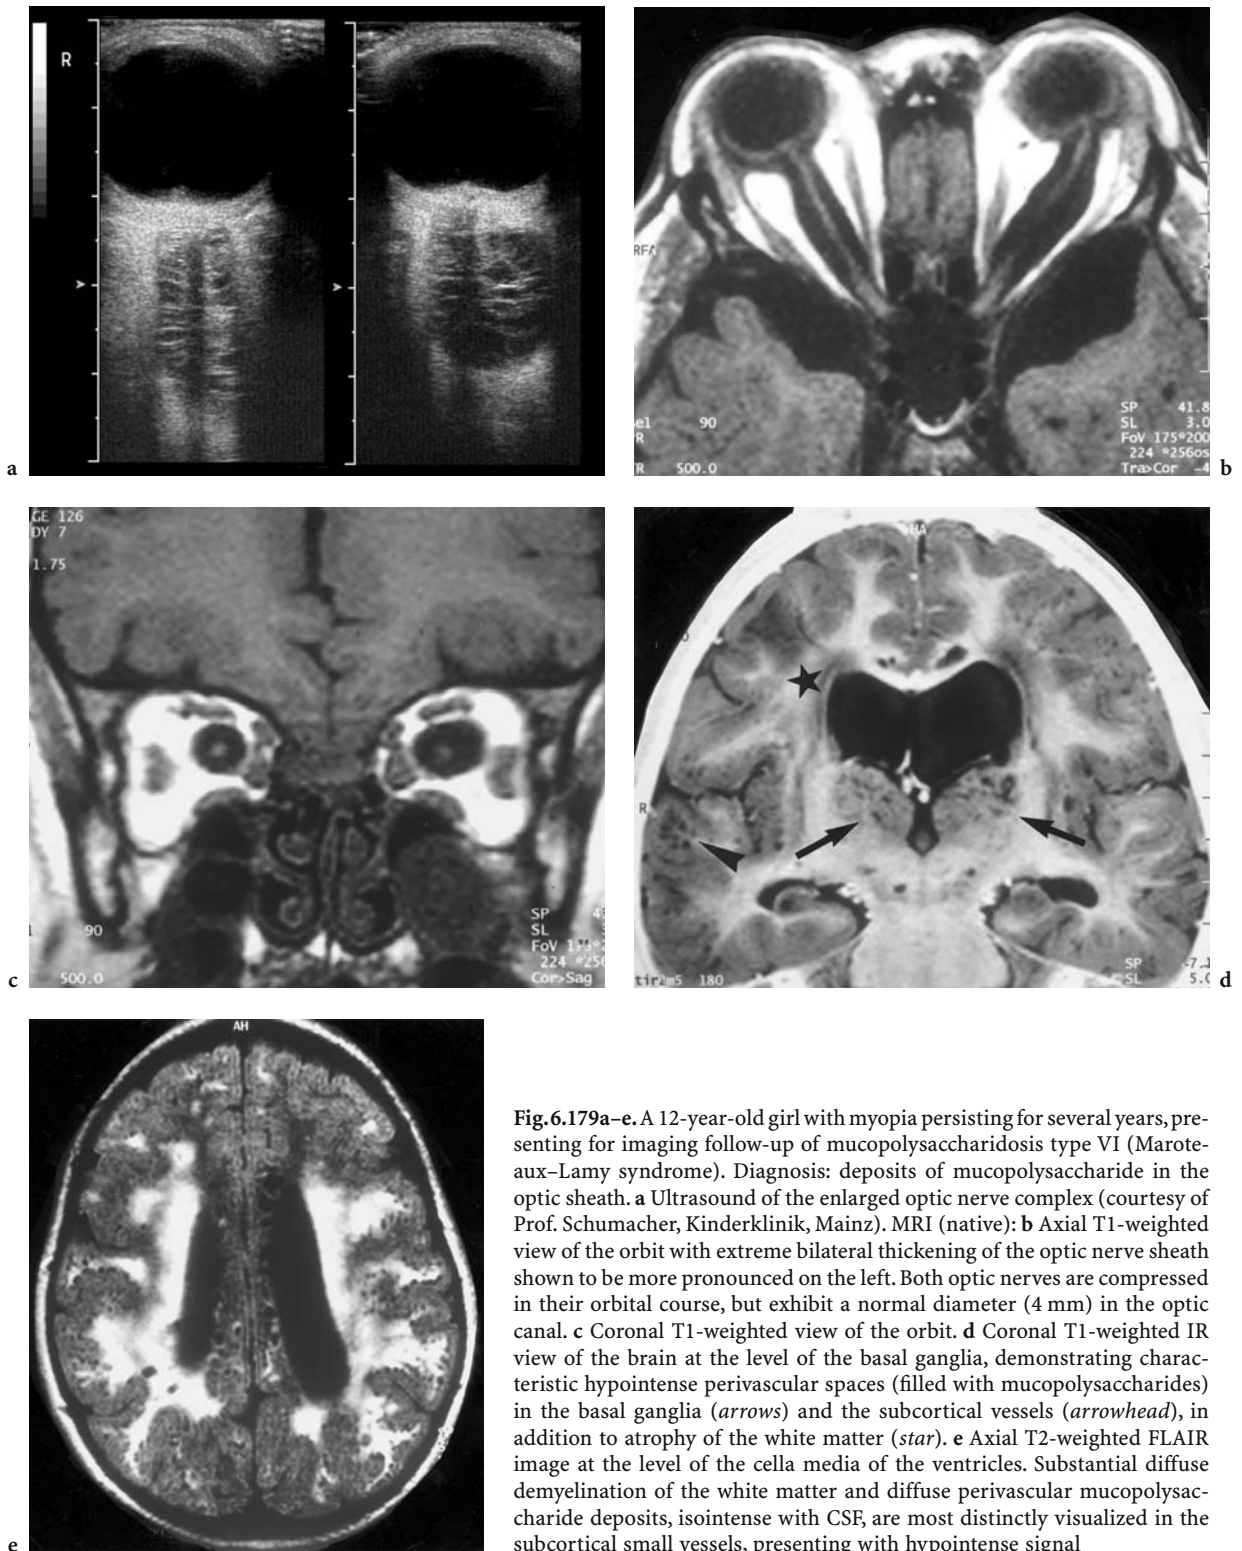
A 12-year-old girl with myopia persisting for several years, presenting for imaging follow-up of mucopolysaccharidosis type VI (Maroteaux–Lamy syndrome). Diagnosis: deposits of mucopolysaccharide in the optic sheath. a Ultrasound of the enlarged optic nerve complex (courtesy of Prof. Schumacher, Kinderklinik, Mainz). MRI (native): b Axial T1-weighted view of the orbit with extreme bilateral thickening of the optic nerve sheath shown to be more pronounced on the left. Both optic nerves are compressed in their orbital course, but exhibit a normal diameter (4 mm) in the optic canal. c Coronal T1-weighted view of the orbit. d Coronal T1-weighted IR view of the brain at the level of the basal ganglia, demonstrating characteristic hypointense perivascular spaces (filled with mucopolysaccharides) in the basal ganglia (*arrows*) and the subcortical vessels (*arrowhead*), in addition to atrophy of the white matter (*star*). e Axial T2-weighted FLAIR image at the level of the cella media of the ventricles. Substantial diffuse demyelination of the white matter and diffuse perivascular mucopolysaccharide deposits, isointense with CSF, are most distinctly visualized in the subcortical small vessels, presenting with hypointense signal
